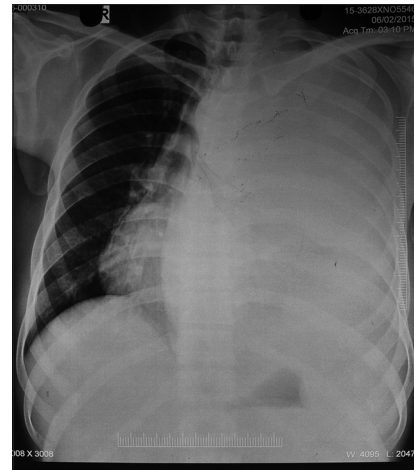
Chest X-ray showing left opaque hemithorax with mediastinal shift to the right
